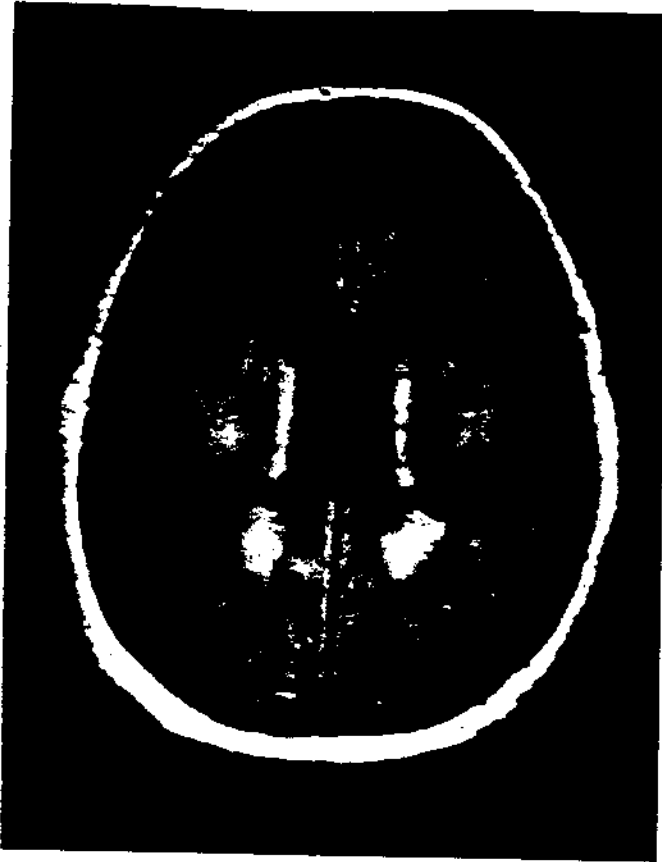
In case 8, a noncontrast, axial, proton-density weighted MRI scan at the level of the superior portion of the lateral ventricles demonstrates a large confluent area of high signal in the right frontotemporoparietal white matter. Confluent areas of high signal are also seen at other sites in the white matter.
